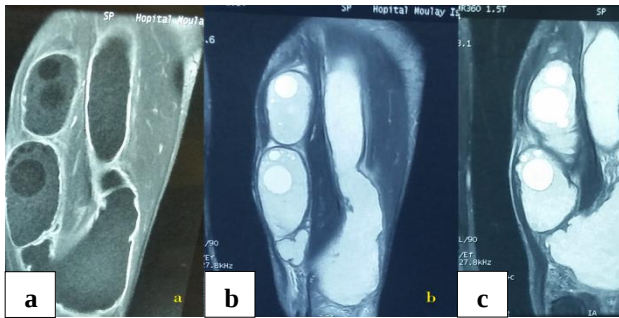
MRI in coronal and axial sections in weighted sequence T1 (a) and T2 (b) two low-signal tumor lesions of the inner surface of the root of the left thigh containing rounded formations. The cystic lesions took contrast after injection of gadolinium (c) with a thick wall and a heterogeneous content. These cystic formations pushed back, without invading them, the superficial femoral vessels inside and the sciatic nerve behind.
